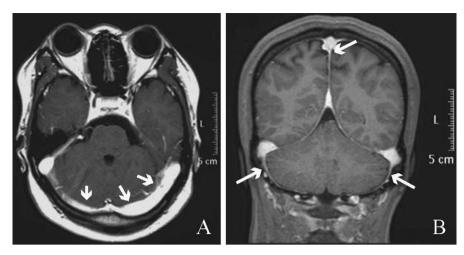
Axial and coronal T1-weighted gadolinium-enhanced MRI findings (A and B) for case 1. Arrows indicate thickening and slight enhancement of the dura mater.
